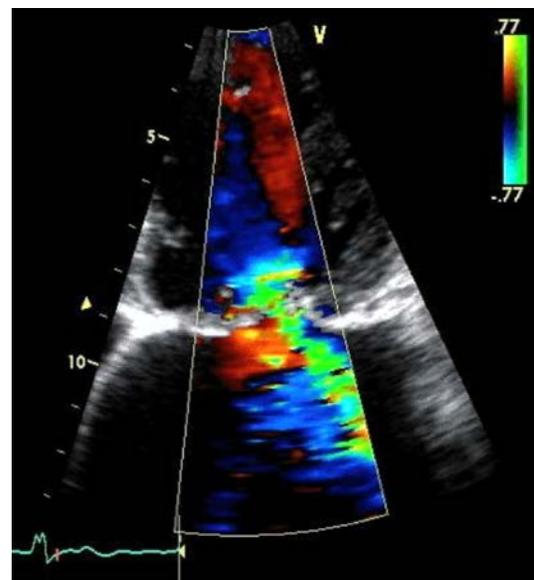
A colour Doppler image of the heart showing the use of variance (displayed in green) to highlight areas with increased spectral broadening. This is likely to be caused by turbulence.
